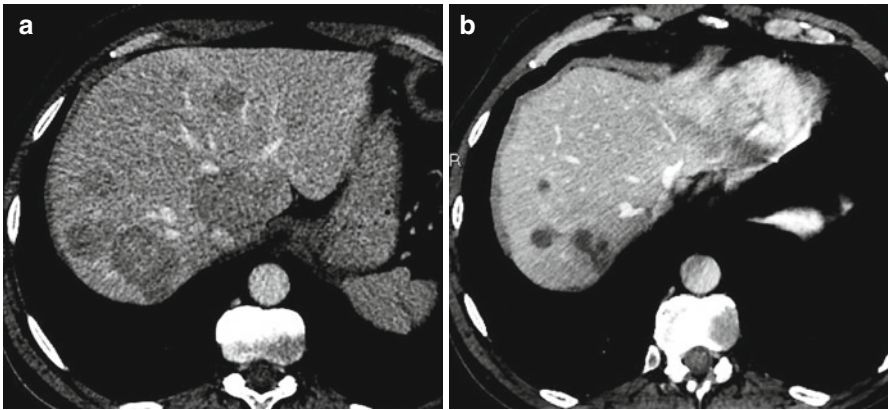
A 56-year-old man with resected small bowel neuroendocrine tumor. (a) Axial CT scan shows hypoattenuating liver metastases (portal venous phase). (b) Axial CT scan at the portal phase after bland embolization of the right liver with sponge shows partial response with important necrosis and decrease in size of all lesions
